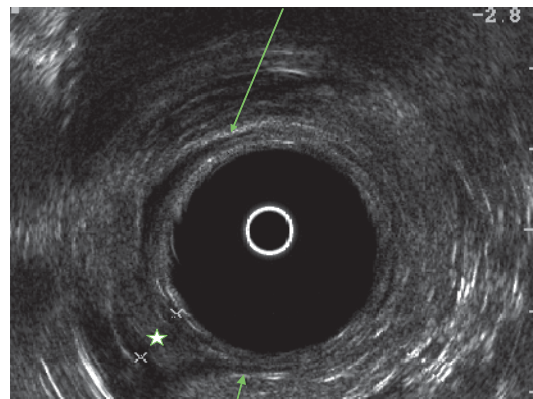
Endorectal ultrasound of a villous lesion (*star*) showing infiltration of the submucosa (*arrow*) confirming an early rectal carcinoma.
